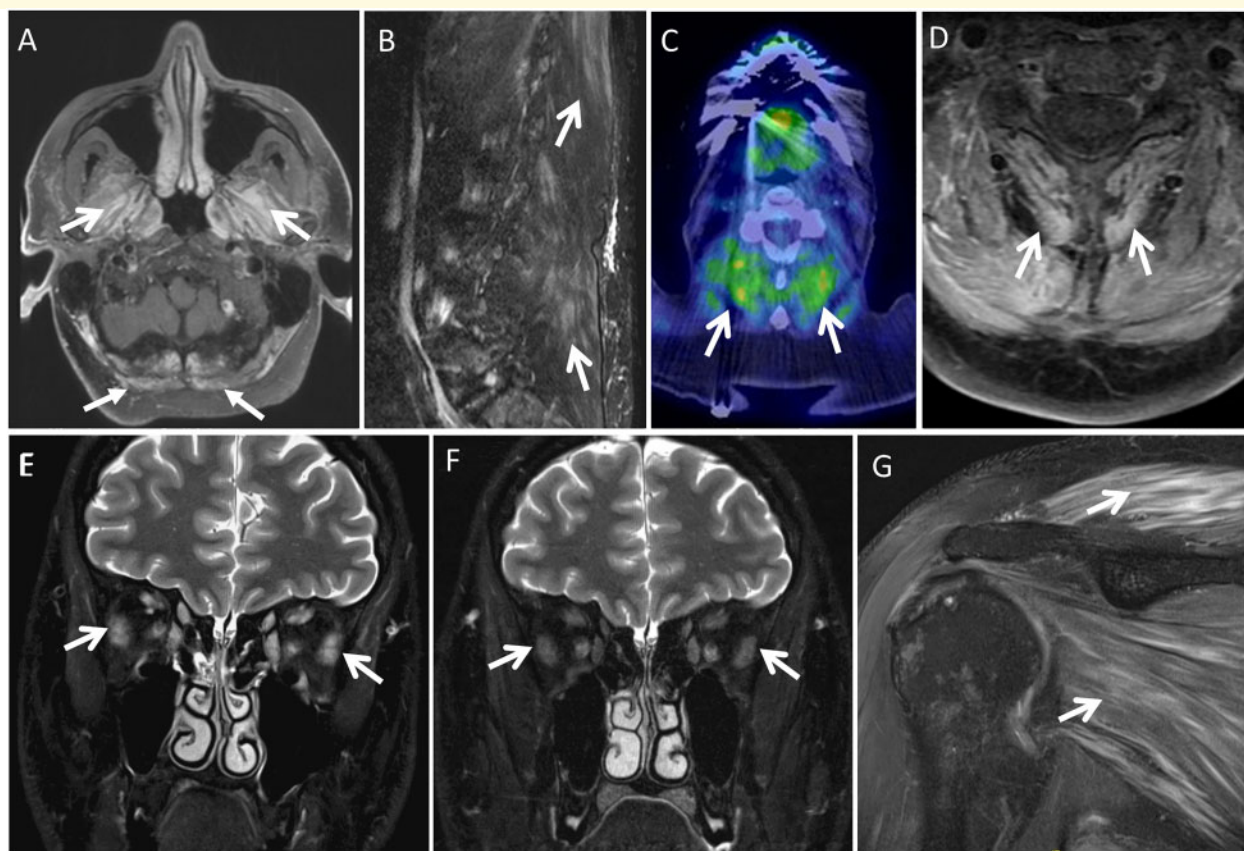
Imaging in ICIAM. Imaging findings of myopathy in five different patients (A–G). (A) Contrast-enhanced axial fat-suppressed T1-weighted brain MRI at the level of foramen magnum reveals contrast enhancement in the muscles of mastication (arrows) and superior posterior neck muscles (block arrows). (B) Off-midline sagittal fat-suppressed T2-weighted lumbar spine MRI demonstrates mild streaky T2-hyperintensity of the lumbar and visualized lower thoracic posterior paraspinal musculature (arrows). (C) Axial 18F-FDG PET CT fused image at C4–5 shows increased FDG uptake in the posterior paraspinal neck musculature (arrows). (D) In the same patient as C, correlative contrast-enhanced axial fat-suppressed T1-weighted cervical spine MRI demonstrates mildly increased enhancement of this posterior paraspinal neck musculature (arrows). (E,F) Coronal fat-suppressed T2-weighted orbit MRI on initial (E) and follow-up (F) initially shows T2 hyperintensity and mild enlargement of the extraocular muscles bilaterally, which resolves on follow-up (arrows on lateral recti). (G) Oblique coronal T2-weighted fat-suppressed shoulder MRI reveals feather like oedema-type T2-hyperintensity enhancement of the shoulder girdle muscles (arrows).
